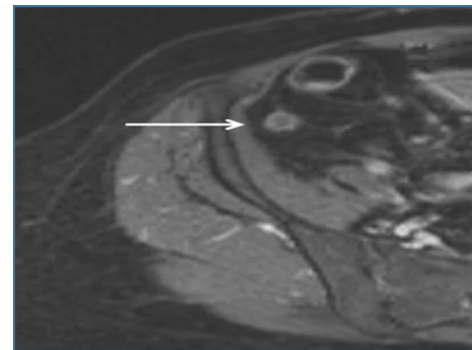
Contrast enhanced MRI of acute appendicitis
